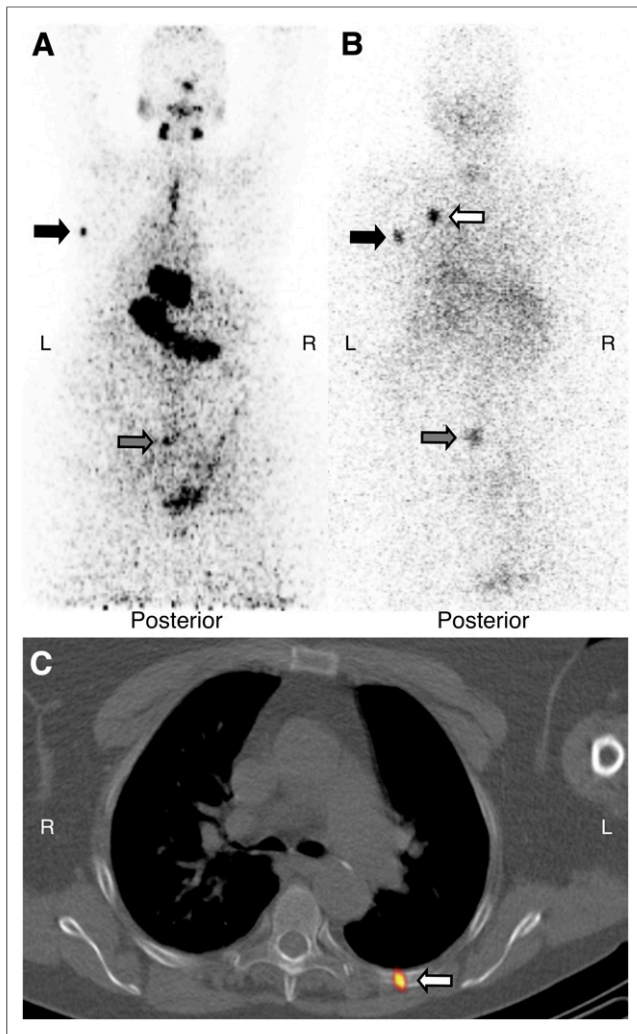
Patient with iodine-positive rib metastasis (focus 5, white arrows) detected not by maximum-intensity-projection ^{124}I PET (A) but by planar ^{131}I WBS (B) and axial SPECT/CT (C). Black arrows mark iodine-positive left scapula metastasis, and gray arrows lower lumbar spine metastasis.
